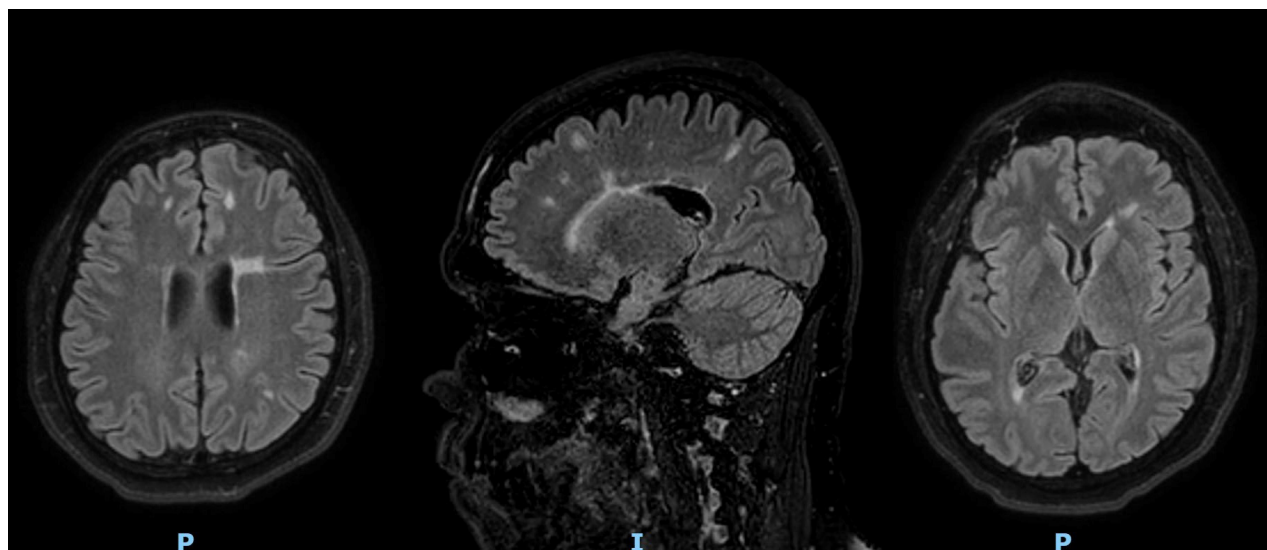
MRI brain, axial and coronal FLAIR, showing the extensive demyelinating lesions with the typical perpendicular Dawson's appearance.
